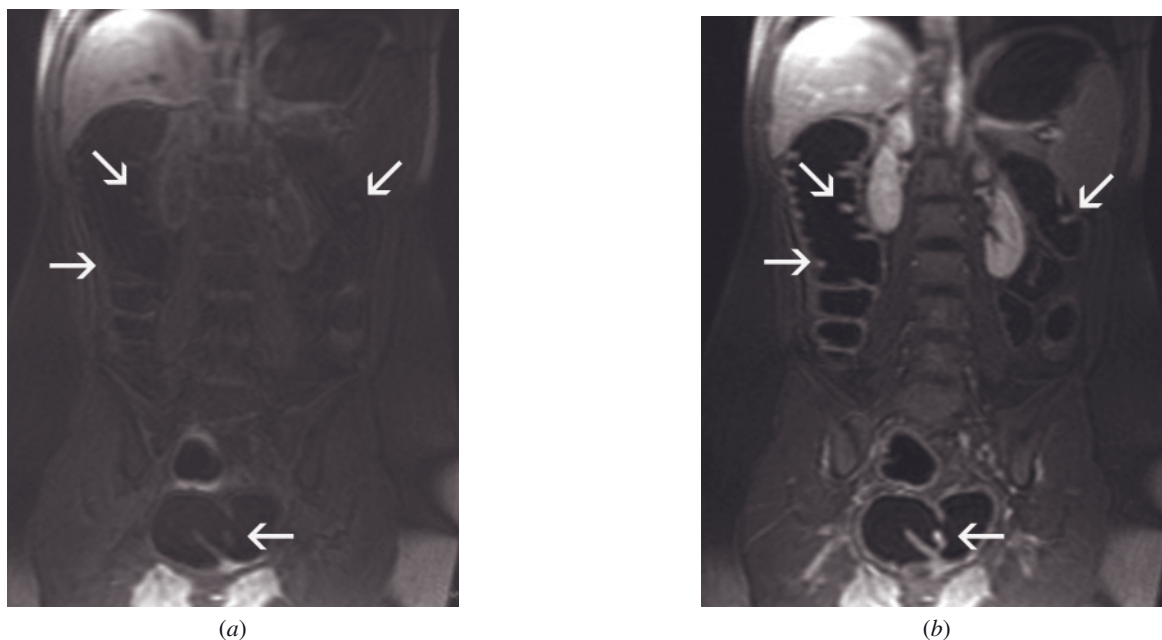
Polyposis coli. With dark-lumen water enema contrast MR colonography, multiple colonic polyps can be detected in this 12-year-old female patient with polyposis coli. These lesions show an avid contrast enhancement comparing precontrast (arrows, *a*) and postcontrast (arrows, *b*) T1-weighted sequences.
